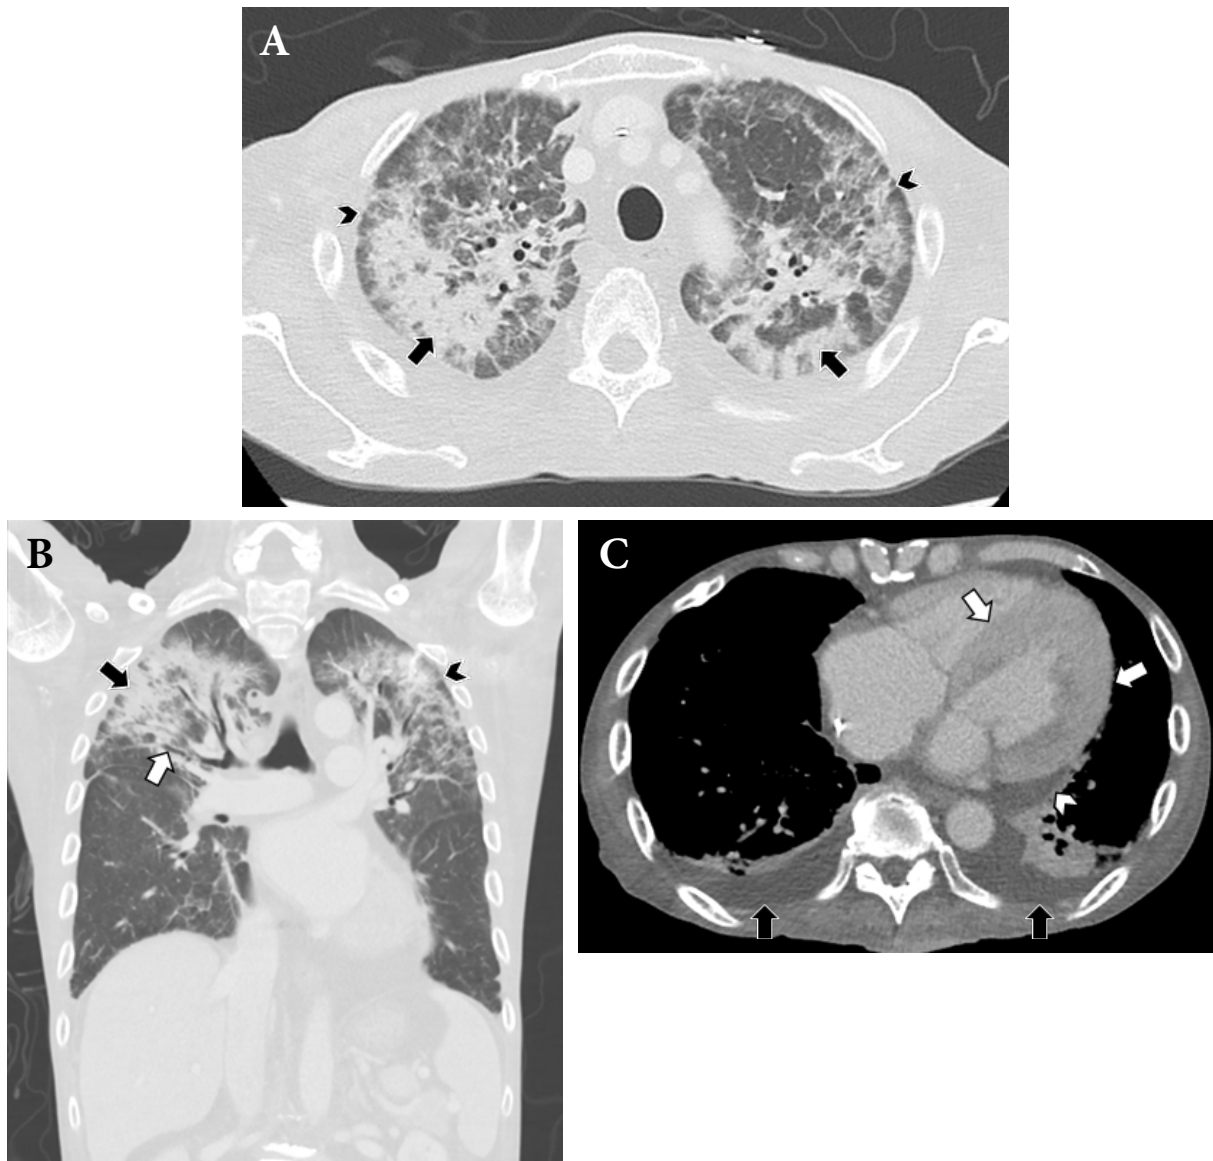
Venous phase chest computed tomography (CT).
